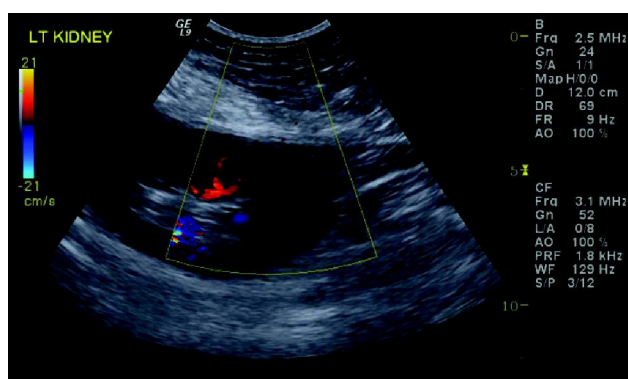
Same patient reevaluated with color doppler ultrasound after one hour for presence of any transient arteriovenous fistula or perinephric hematoma showing no complication.
